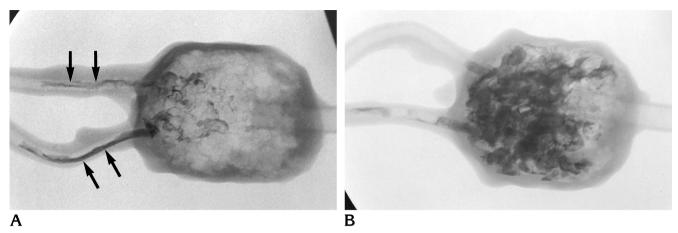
A, Radiograph of unsuccessful first treatment. Note complete proximal pedicle occlusion (*arrows*). B, After five additional training sessions, posttreatment radiograph shows satisfactory penetration of the nidus by the glue.
